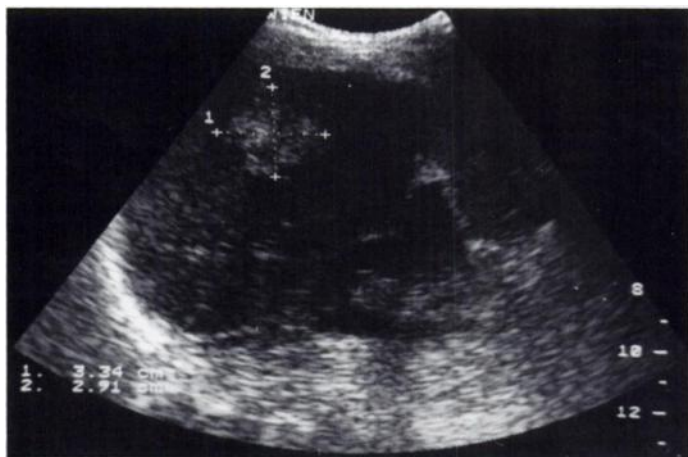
Sonographic finding indicates the hyperechoic liver lesion suspicious of a hemangioma.
